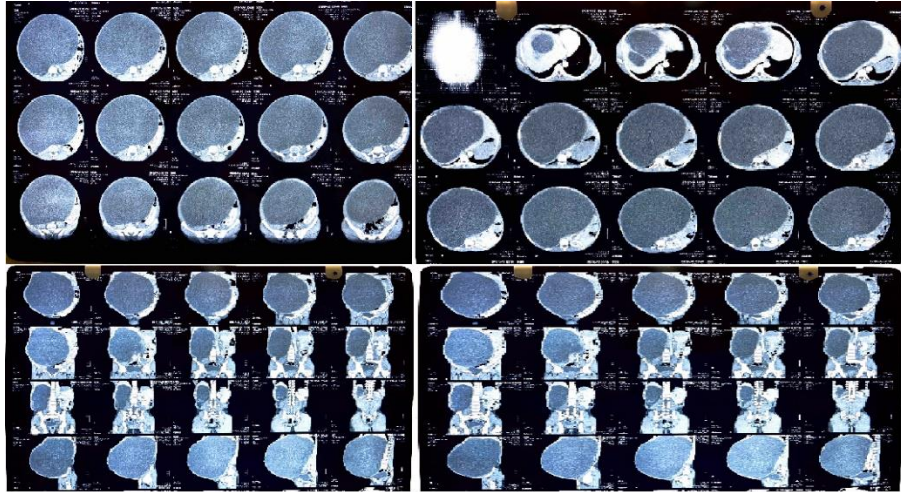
Abdominal computed tomography.
